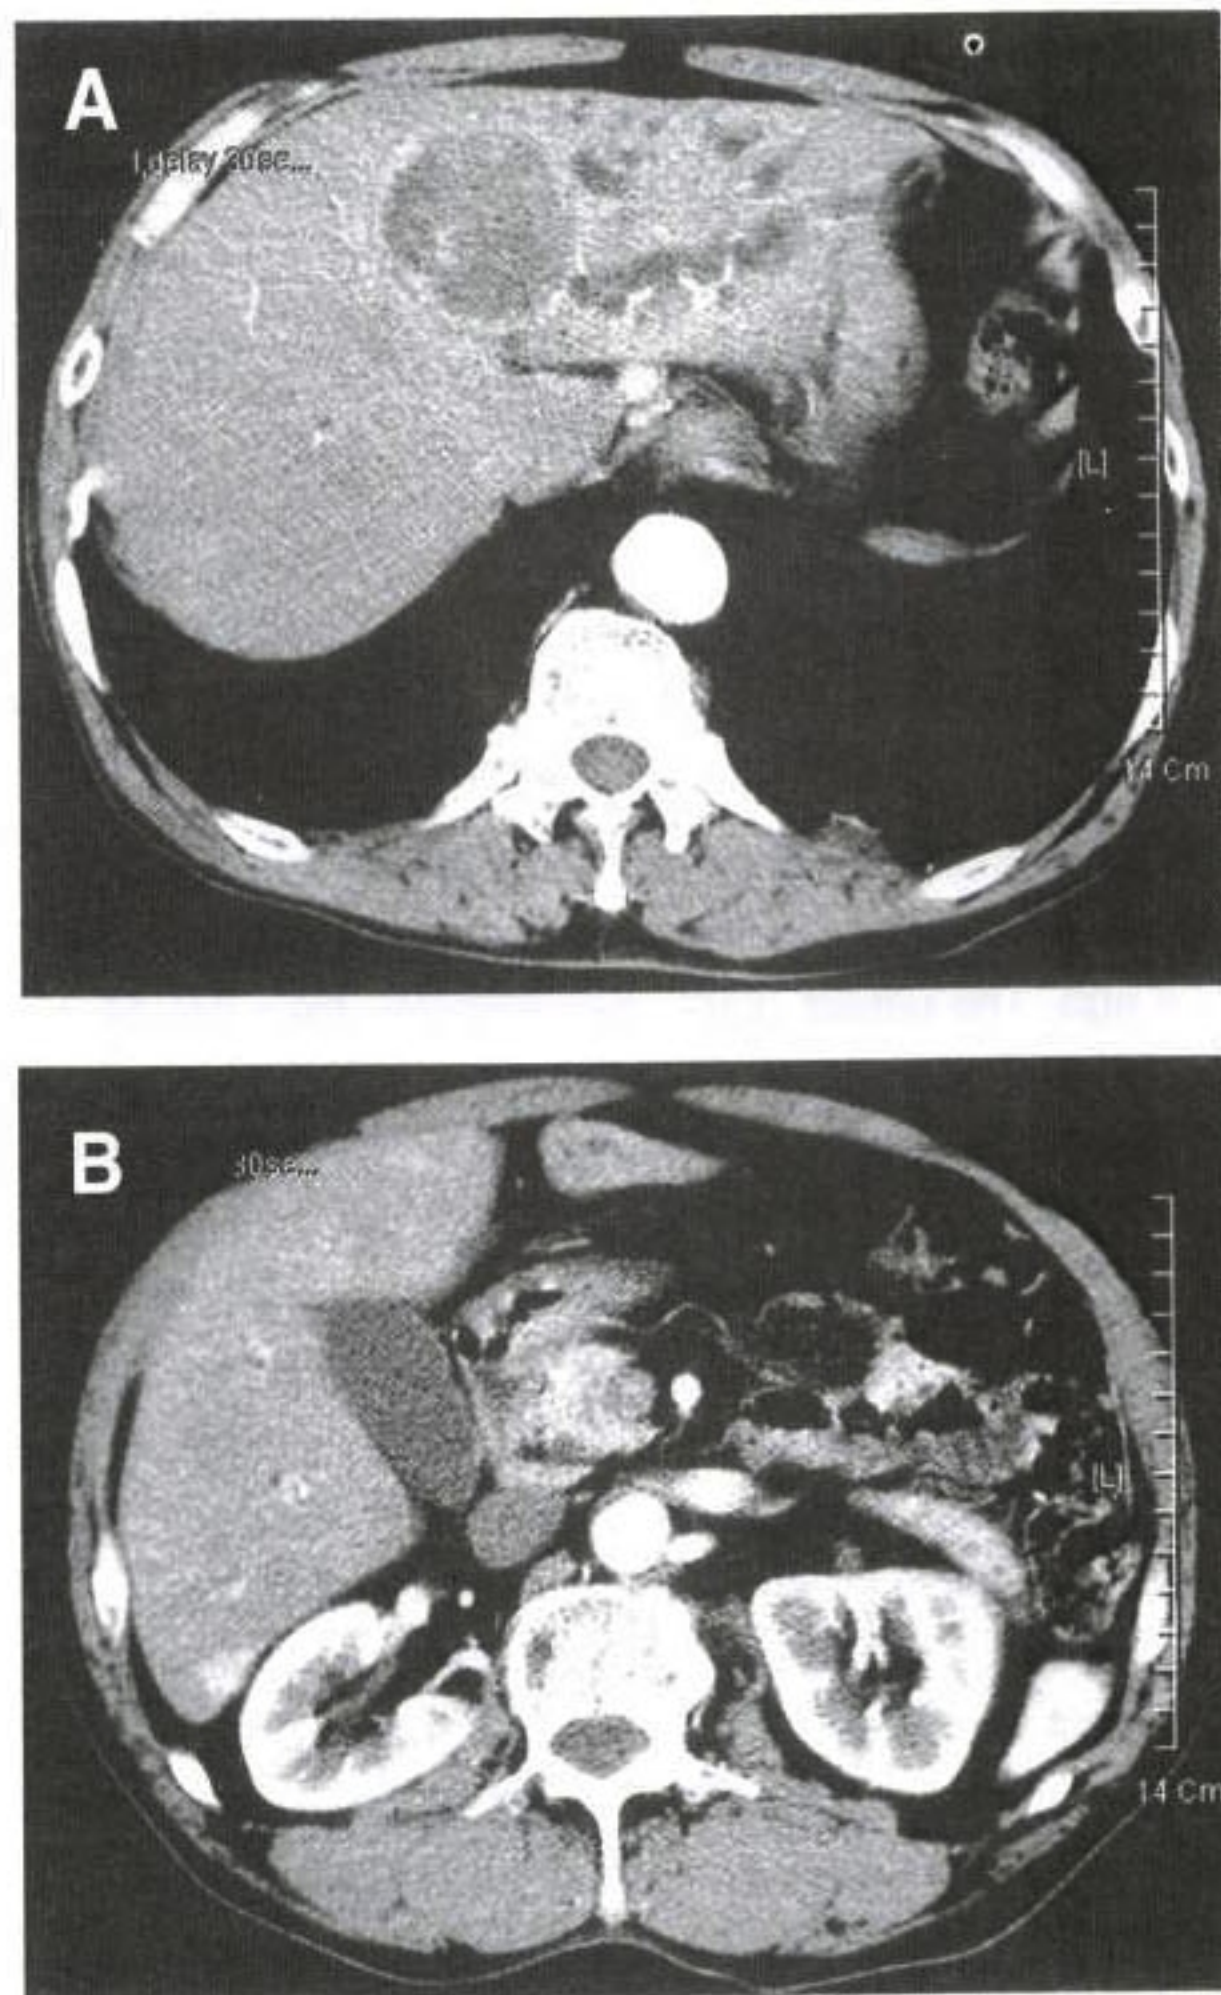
Abdominal CT finding. (A) Arterial phase. It shows a 6×5 cm mass with relatively discrete margin in the left medial segment of the liver. The left hepatic duct was encased by the mass and there was diffuse dilatation of intrahepatic bile ducts in the left lobe. (B) Arterial phase. It shows a small early enhanced mass in right posteroinferior segment.
